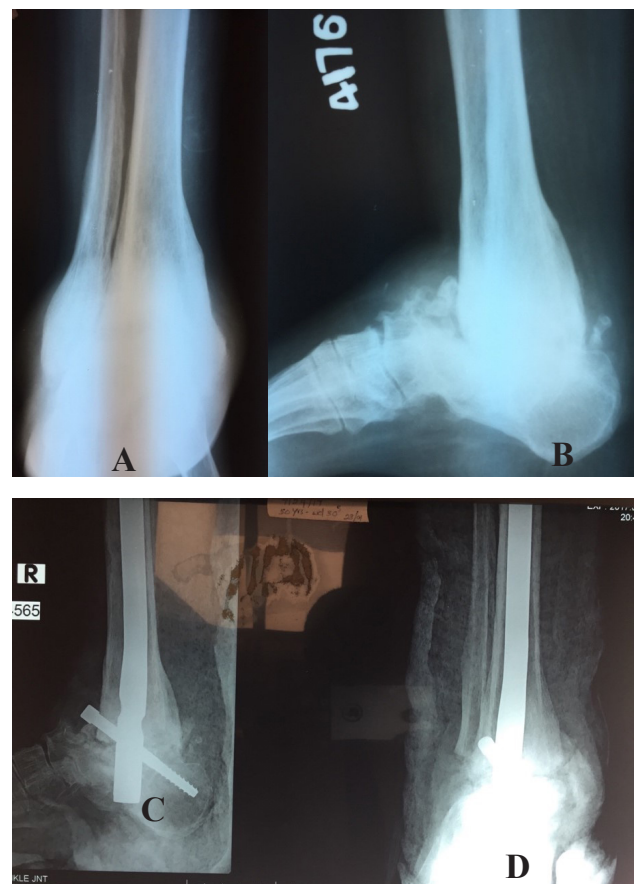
shows a collection of images of radiographs and clinical photographs of the patient 2. Figures 2A and 2B show pre-operative radiographs of the ankle with severe degeneration of the ankle, complete lysis of the talus, and severe secondary osteoarthritis. Figure 2C&D shows immediate post-operative radiographs with good reduction and compression at the fusion sites. Figure 2E shows good fusion at 02 years. Figures 2F&G show clinical photographs at 02 years with a painless plantigrade foot.
